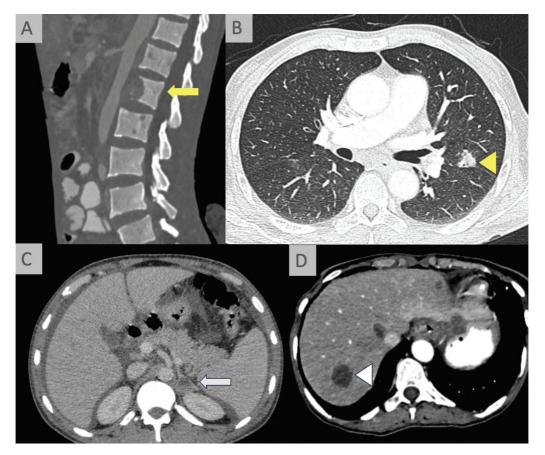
Distant metastases in esophageal cancer. Sagittal (A) and axial (B–D) contrast-enhanced computed tomography (CT) shows multiple lytic lesions in the bodies of distal thoracic vertebrae (yellow arrow, A), a random nodule with indistinct margins in the left lung (yellow arrowhead, B), hypodense lesion in the left adrenal gland (white arrow, C), and multiple hypodense lesions in the liver (white arrowhead, D).
